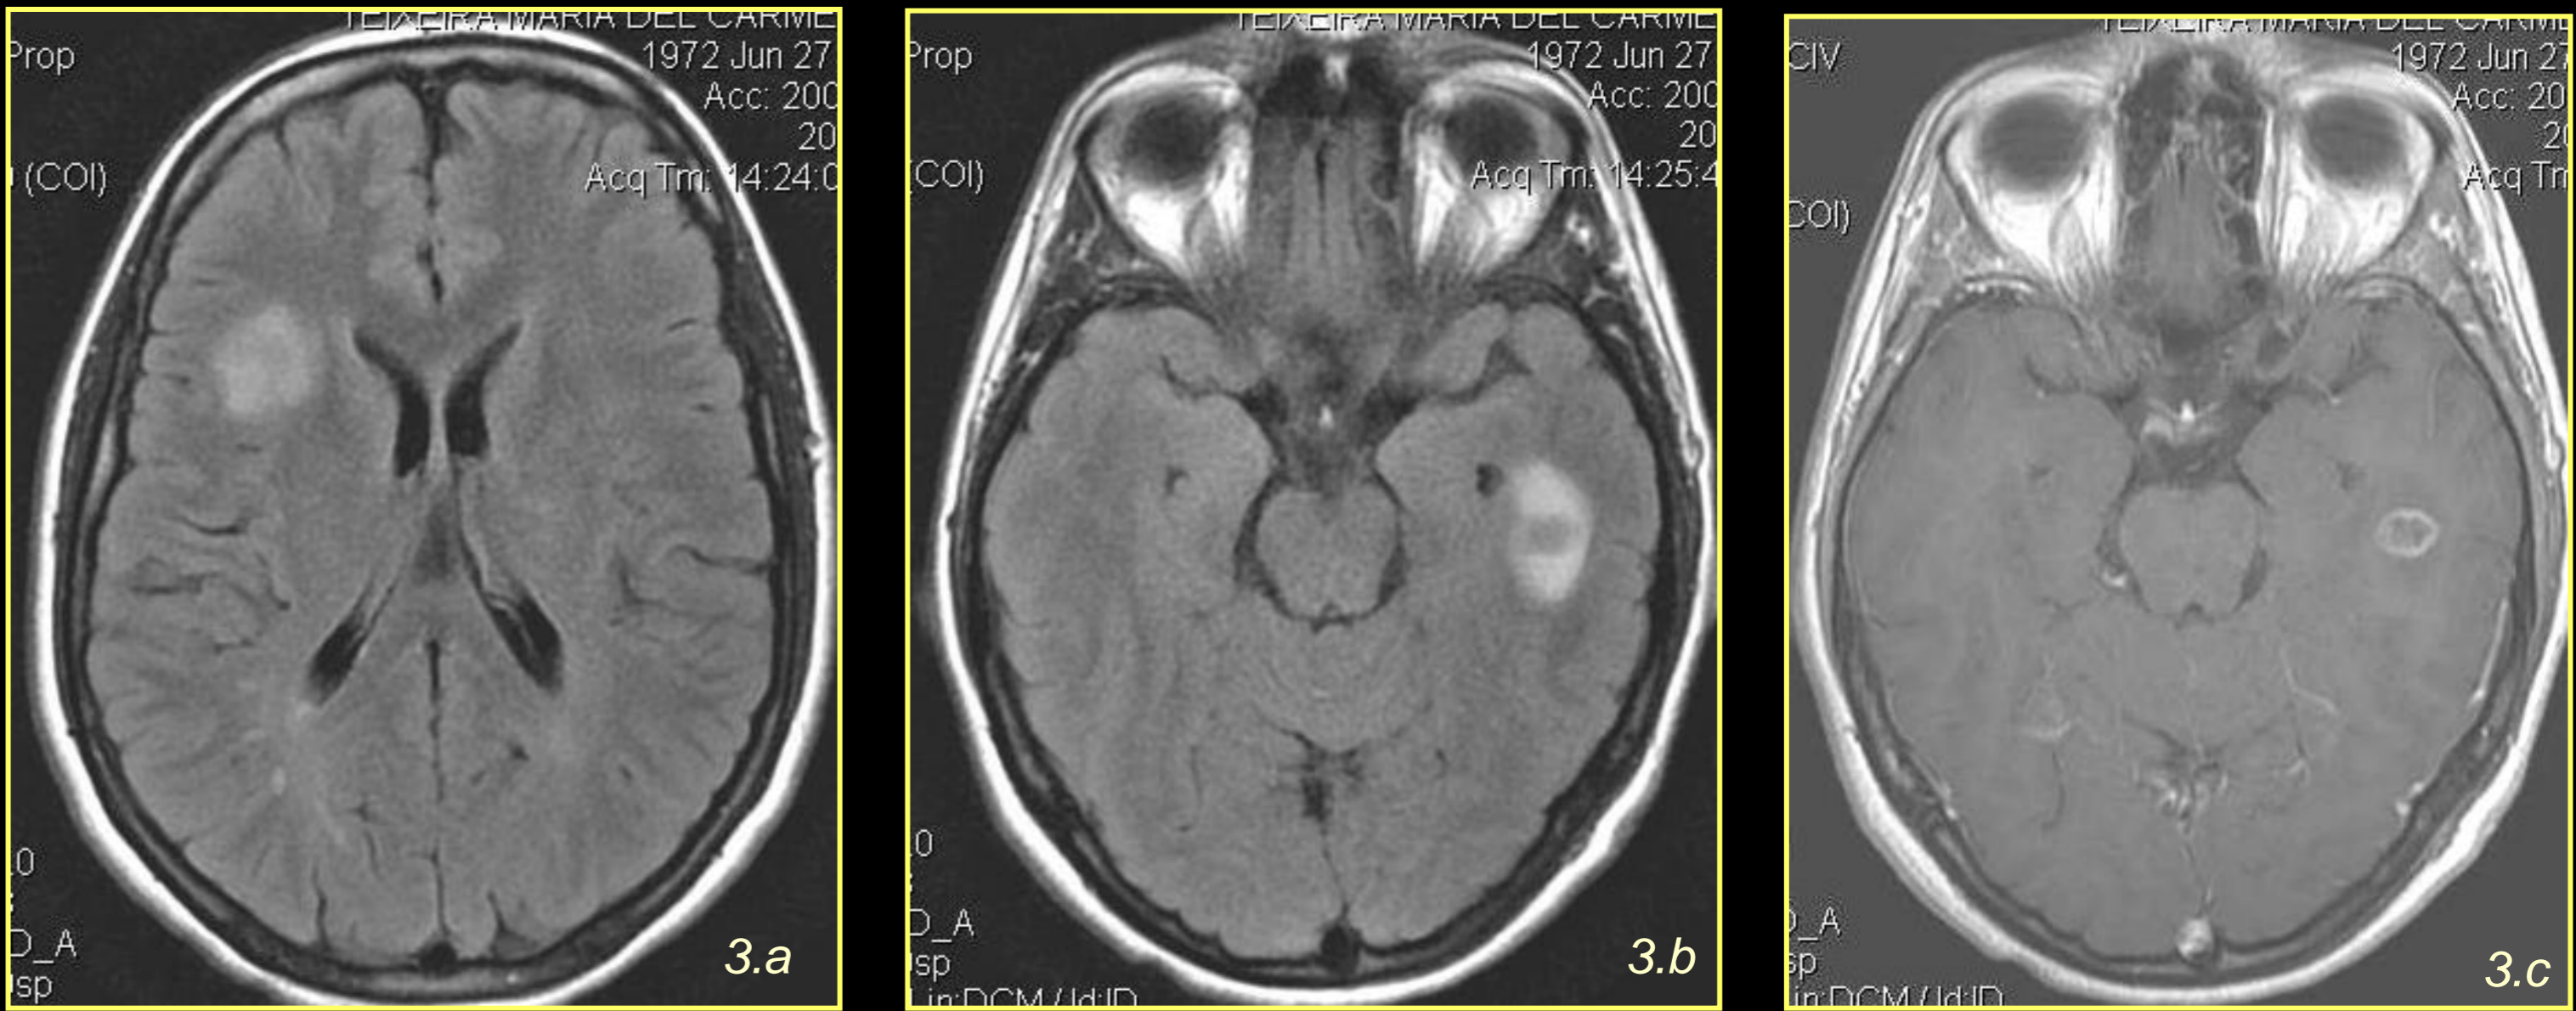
A 36-year-old woman with sensory changes. a) and b) Axial FLAIR images. c) Axial post-contrast T1-WI.
